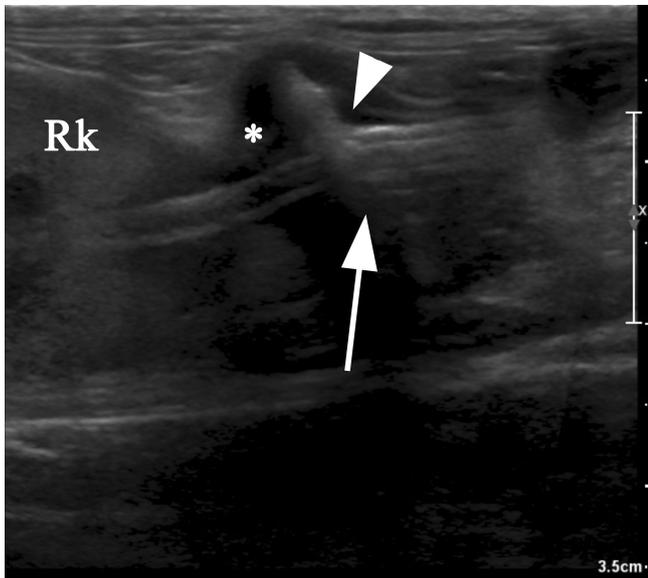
Ultrasonographic image of the nephrostomy tube of the subcutaneous ureteral bypass that migrated into the duodenal wall. The Dacron cuff (arrow) is visible inside the intestinal lumen (arrowhead). The loss of the intestinal layered structure (asterisk) between the cuff and the right kidney (Rk) is the presumed site of transmural migration. The proximal part of the nephrostomy tube is still in place inside the renal pelvis. The surrounding fat is hyperechoic indicating a concurrent focal peritonitis
